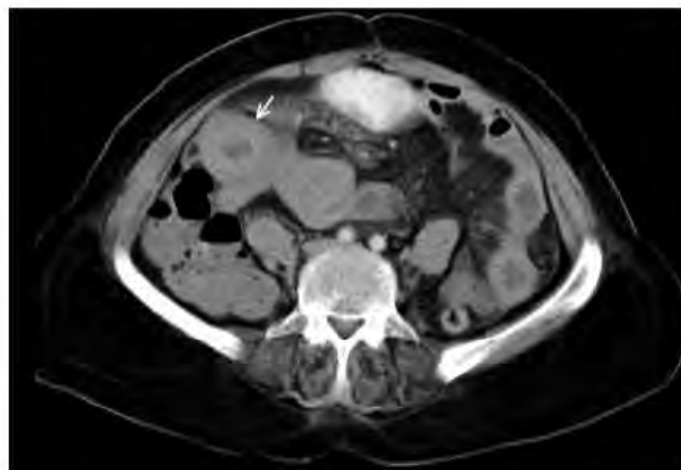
Abdominal computed tomography view. (Arrow shows thick small bowel segment)
